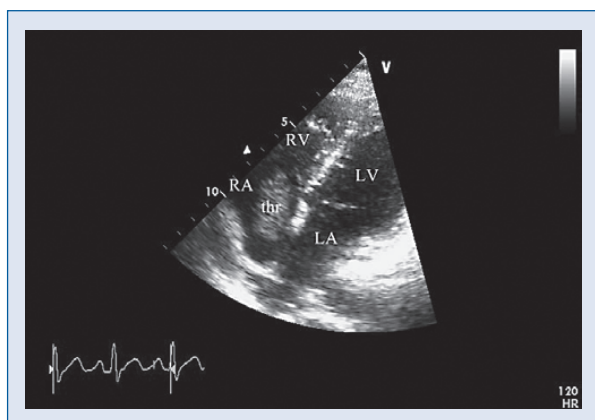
Transthoracic echocardiography, apical 4-chamber view showing a huge oval free-floating thrombus (thr) in the right atrium (RA), and occupying most of the right atrial cavity; LA — left atrium; LV — left ventricle; RV — right ventricle.
